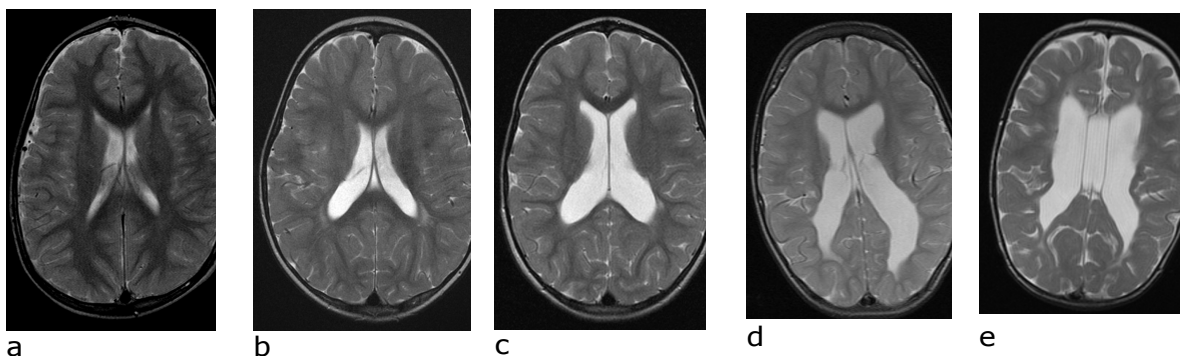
Axial T2-weighted MR images: show the optic classification of the extension of the lateral ventricle according to the width with grade 1 the least and grade 5 the most grade. a: grade 1, b: grade 2, c: grade 3, d: grade 4, e: grade 5.
